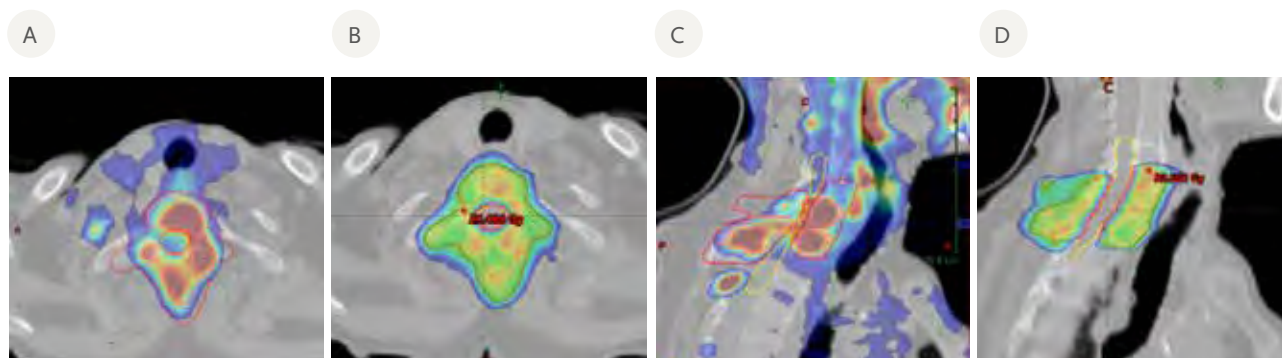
SBRT of a vertebral metastasis. In the upper images fusion of PET scan and planning CT. In B and D images dose distribution. Dose prescription of 24 Gy in 2 fractions.
